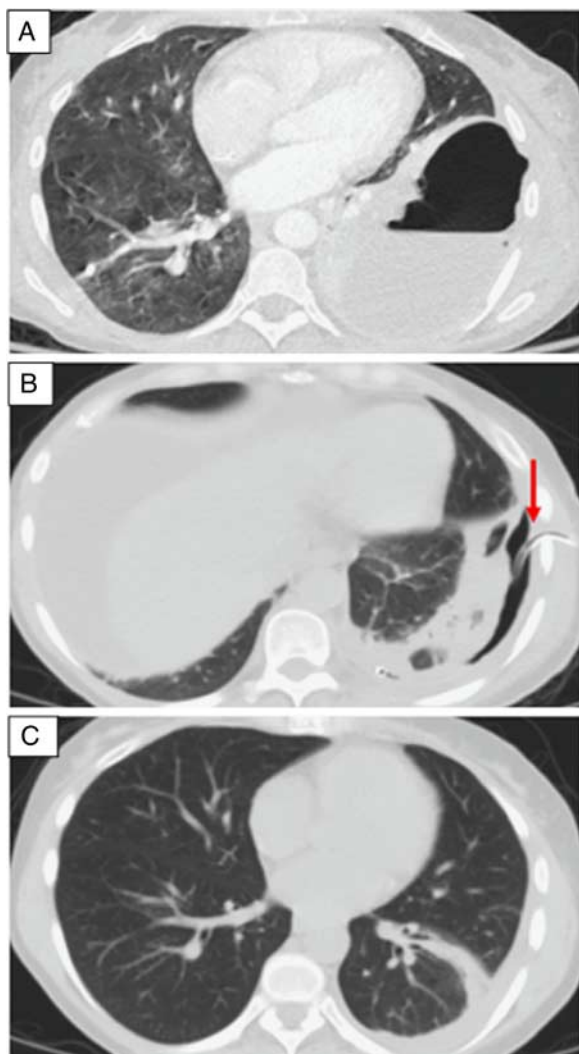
Chest computed tomographic scanning images showing pleural space infection and a non-expandable lung, managed with medical treatment and TPC drainage. A, Image upon admission. B, TPC in place (red arrow), after 18 days of therapy initiation. C, Resolution of the infection after 68 days following therapy and TPC removal. TPC indicates tunneled pleural catheter. *u+*
